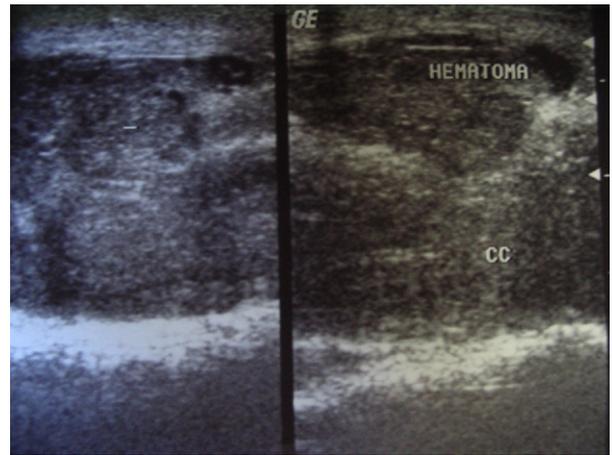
Penile ultrasound of a patient from G2 (high suspicion of penile fracture). The ultrasound image shows rupture of the tunica albuginea with a large hematoma. CC, corpus cavernosum.
